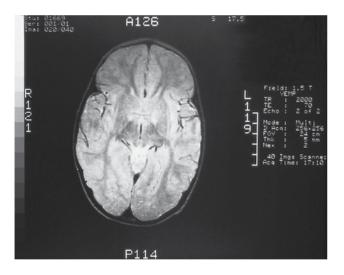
MRI of the brain of TJ revealed increased intensity of T₂ signal in the basal ganglia.
